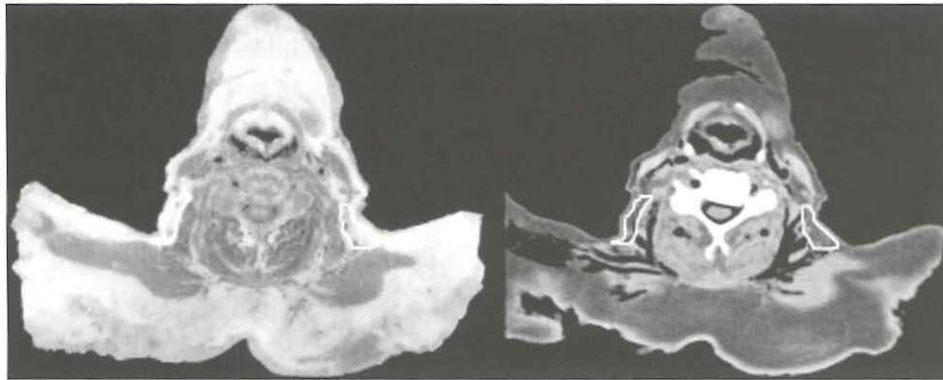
Region 5 (posterior triangle lymph nodes): The borders of this region are outlined on a transversal anatomy slice (left panel) and the matched CT slice (right panel), in between the cranial (cranial CT slice through vertebra C-1) and caudal (2 cm cranial to sternoclavicular joint) borders. The borders are discussed in the text and in Table 1.
